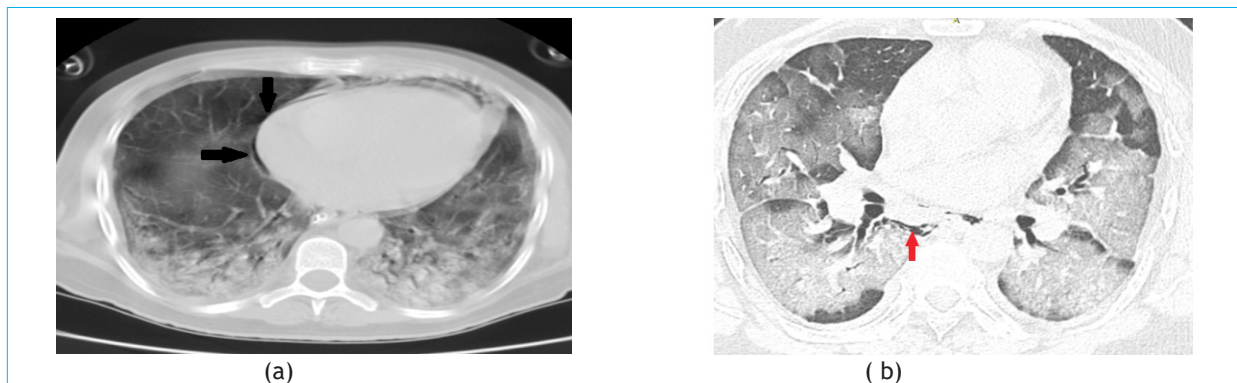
(a) and (b). Axial HRCT images show pneumopericardium (black arrows) and air along the peribronchial sheath of superior segmental bronchi of right lower lobe (red arrow). Predominant peripheral consolidation and ground glass opacities related to COVID-19 are seen.
